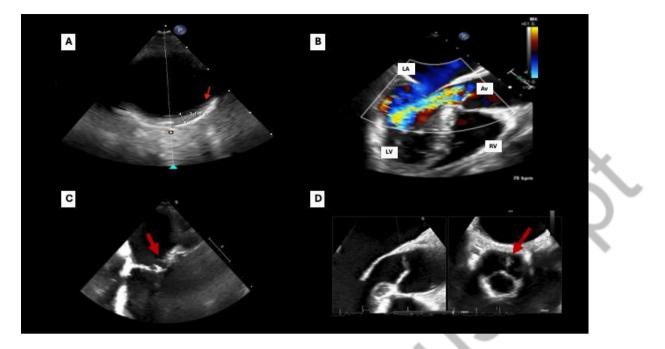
A) Transoesophageal echocardiogram images showing thickening of the aortic wall (arrow), suggesting large-vessel vasculitis. B) Transoesophageal echocardiogram showing severe aortic regurgitation. C) and D) Transoesophageal echocardiographic views of the vegetation at the level of the aortic valve (arrows). RV (right ventricle); LA (left atrium); LV (left ventricle); Av (aortic valve).
